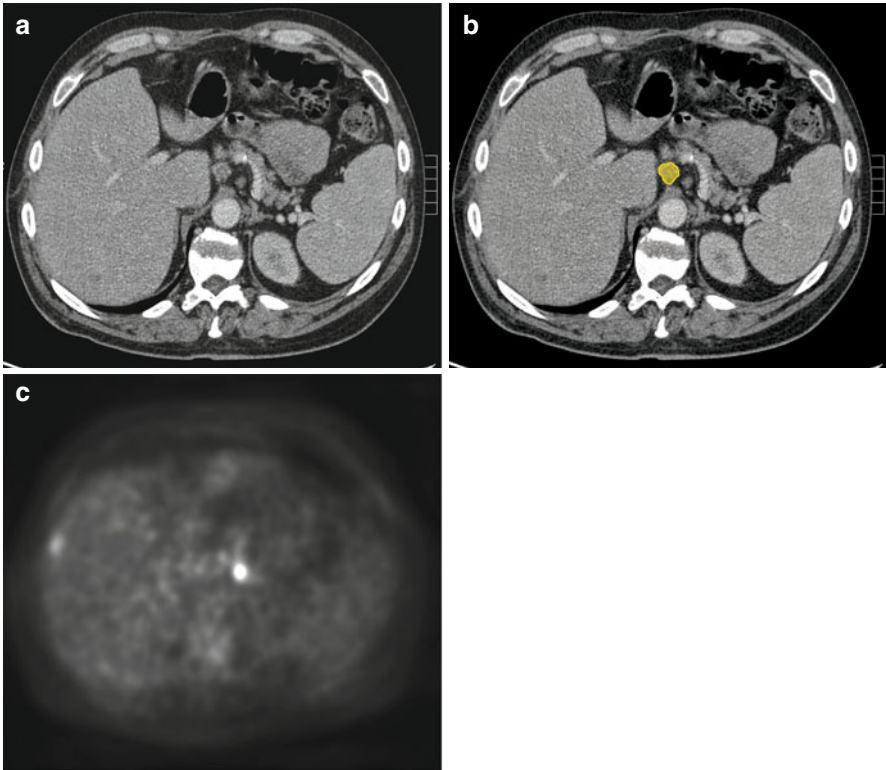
(a–c) Axial CT image in a patient with esophageal cancer shows enlarged celiac lymph node (yellow). The node shows FDG activity on a PET scan
